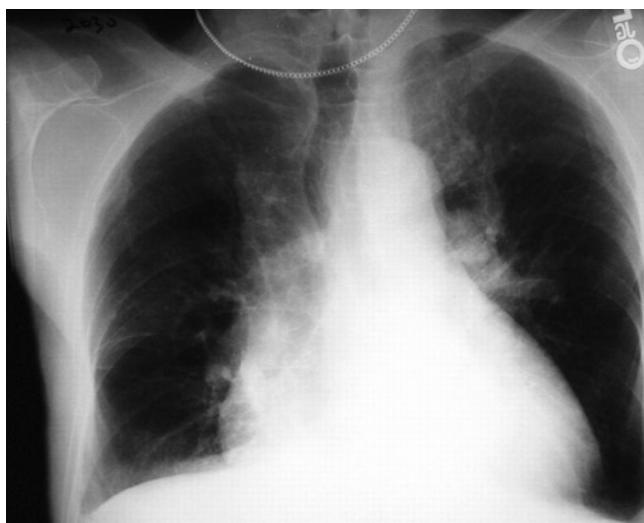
Chest radiograph of a patient with advanced chronic thromboembolic pulmonary hypertension. Cardiomegaly, hilar fullness, and decrease in vascularity in areas of the lung fields are apparent.
